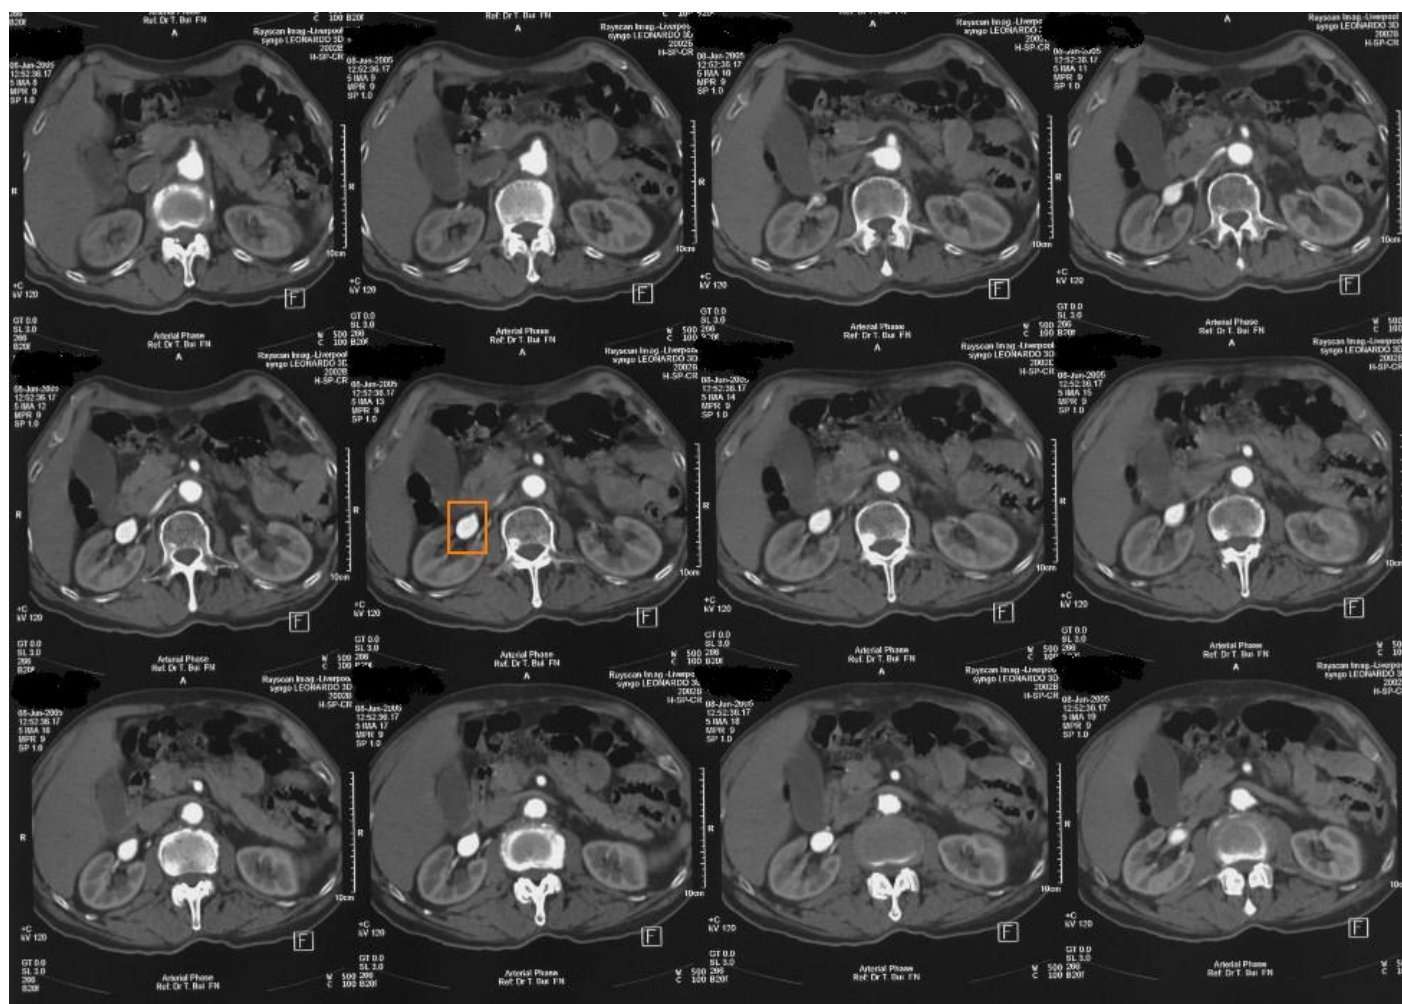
Axial images of contrast computed tomography of a 77-year-old male with hypertension showing an oval right renal artery aneurysm measuring 2.5cm in diameter (highlighted by orange rectangle).
